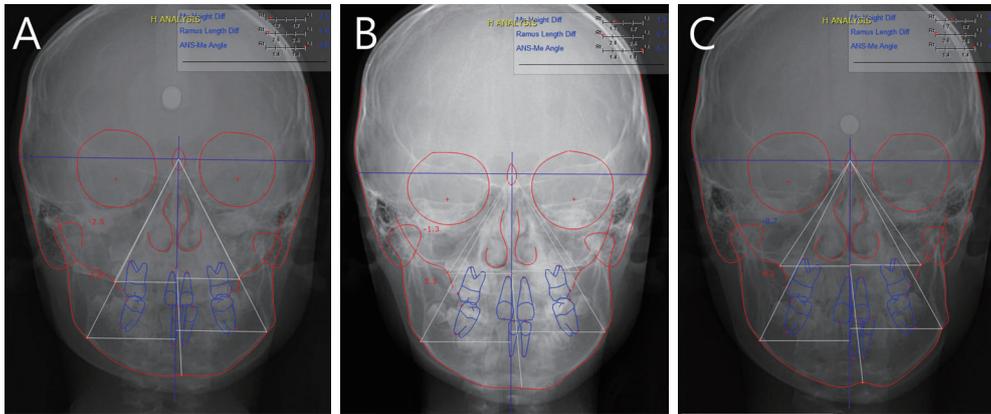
A Series of Anteroposterior cephalometric radiographs. (A) 3 years after trauma, (B) 4 years after trauma, (C) 6 years after trauma. From this time on, a hybrid appliance was used.
